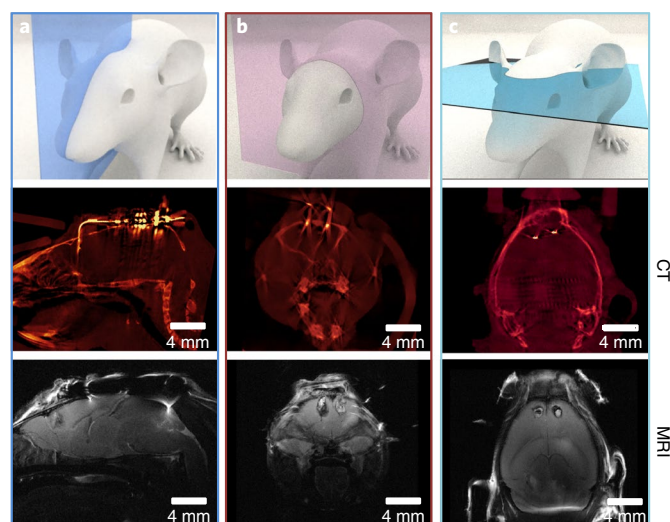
MRI and CT imaging results of the bilateral multi μ -ILED device. a, Sagittal orientation. b, Axial orientation. c, Coronal orientation.
